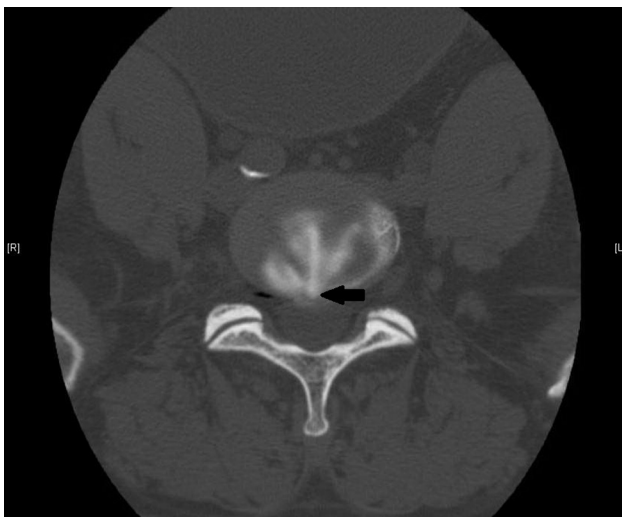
Postdiskography computed tomography axial cut demonstrating posterior, midline radial fissure (arrow) with circumferential outer annular extension.
